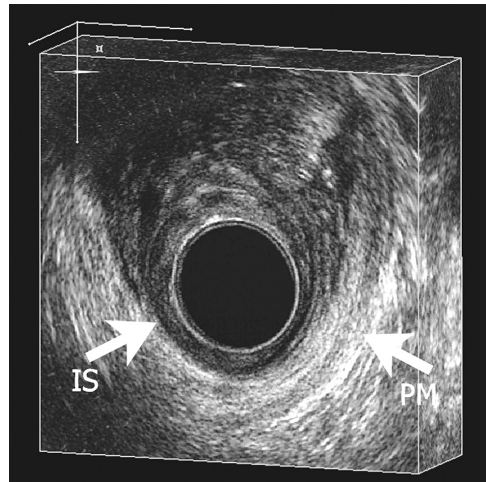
Three-dimensional endoanal ultrasonography at the proximal anal canal from a 60-years-old man demonstrating normal anatomy of the puborectal muscle (PM), visualized as a sling-like structure. The top of the figure is anterior. IS = internal anal sphincter
